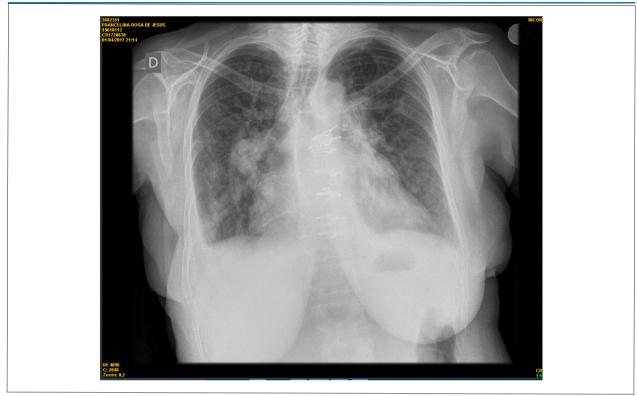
Chest radiography - right perihilar condensation and right cardiac border, signs of pulmonary congestion and cardiomegaly.
